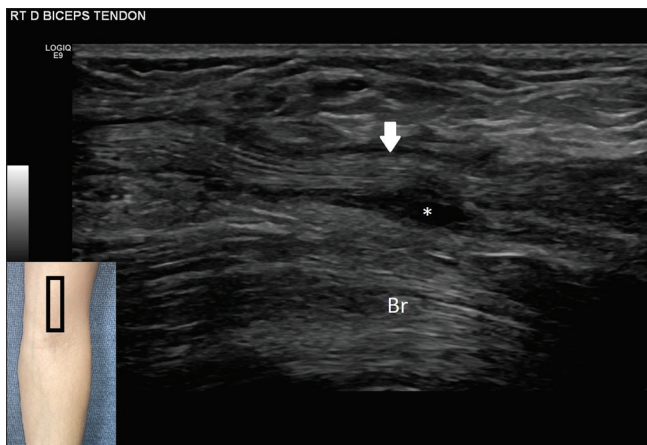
Longitudinal ultrasound image of the distal biceps tendon showing a corrugated appearance (arrow) with fluid and hematoma in the paratenon (asterisk). Br: Brachialis muscle
